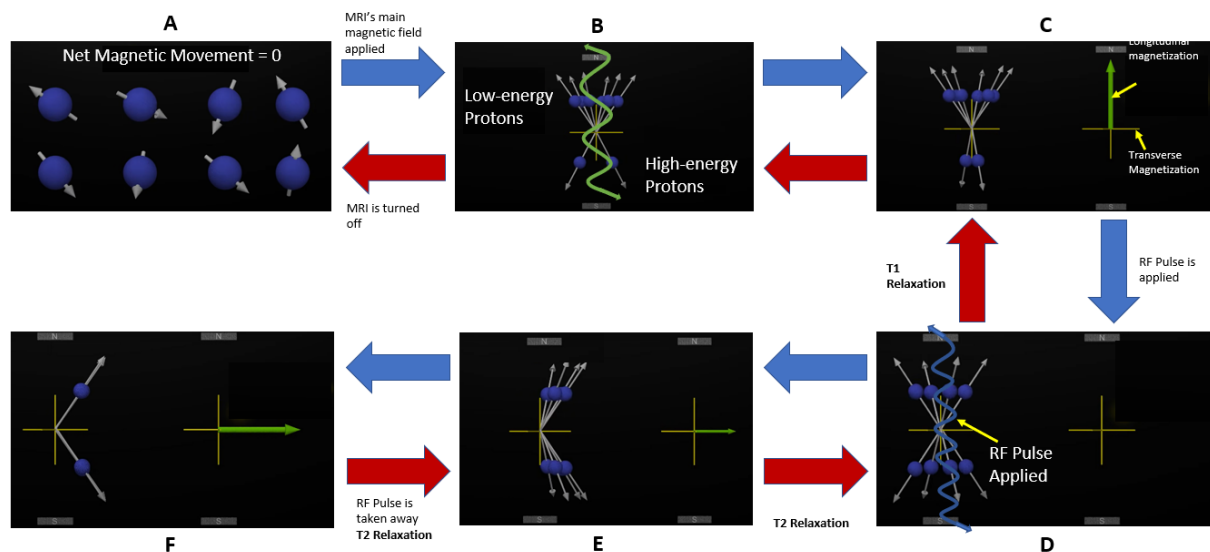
¹² MRI Signaling process
